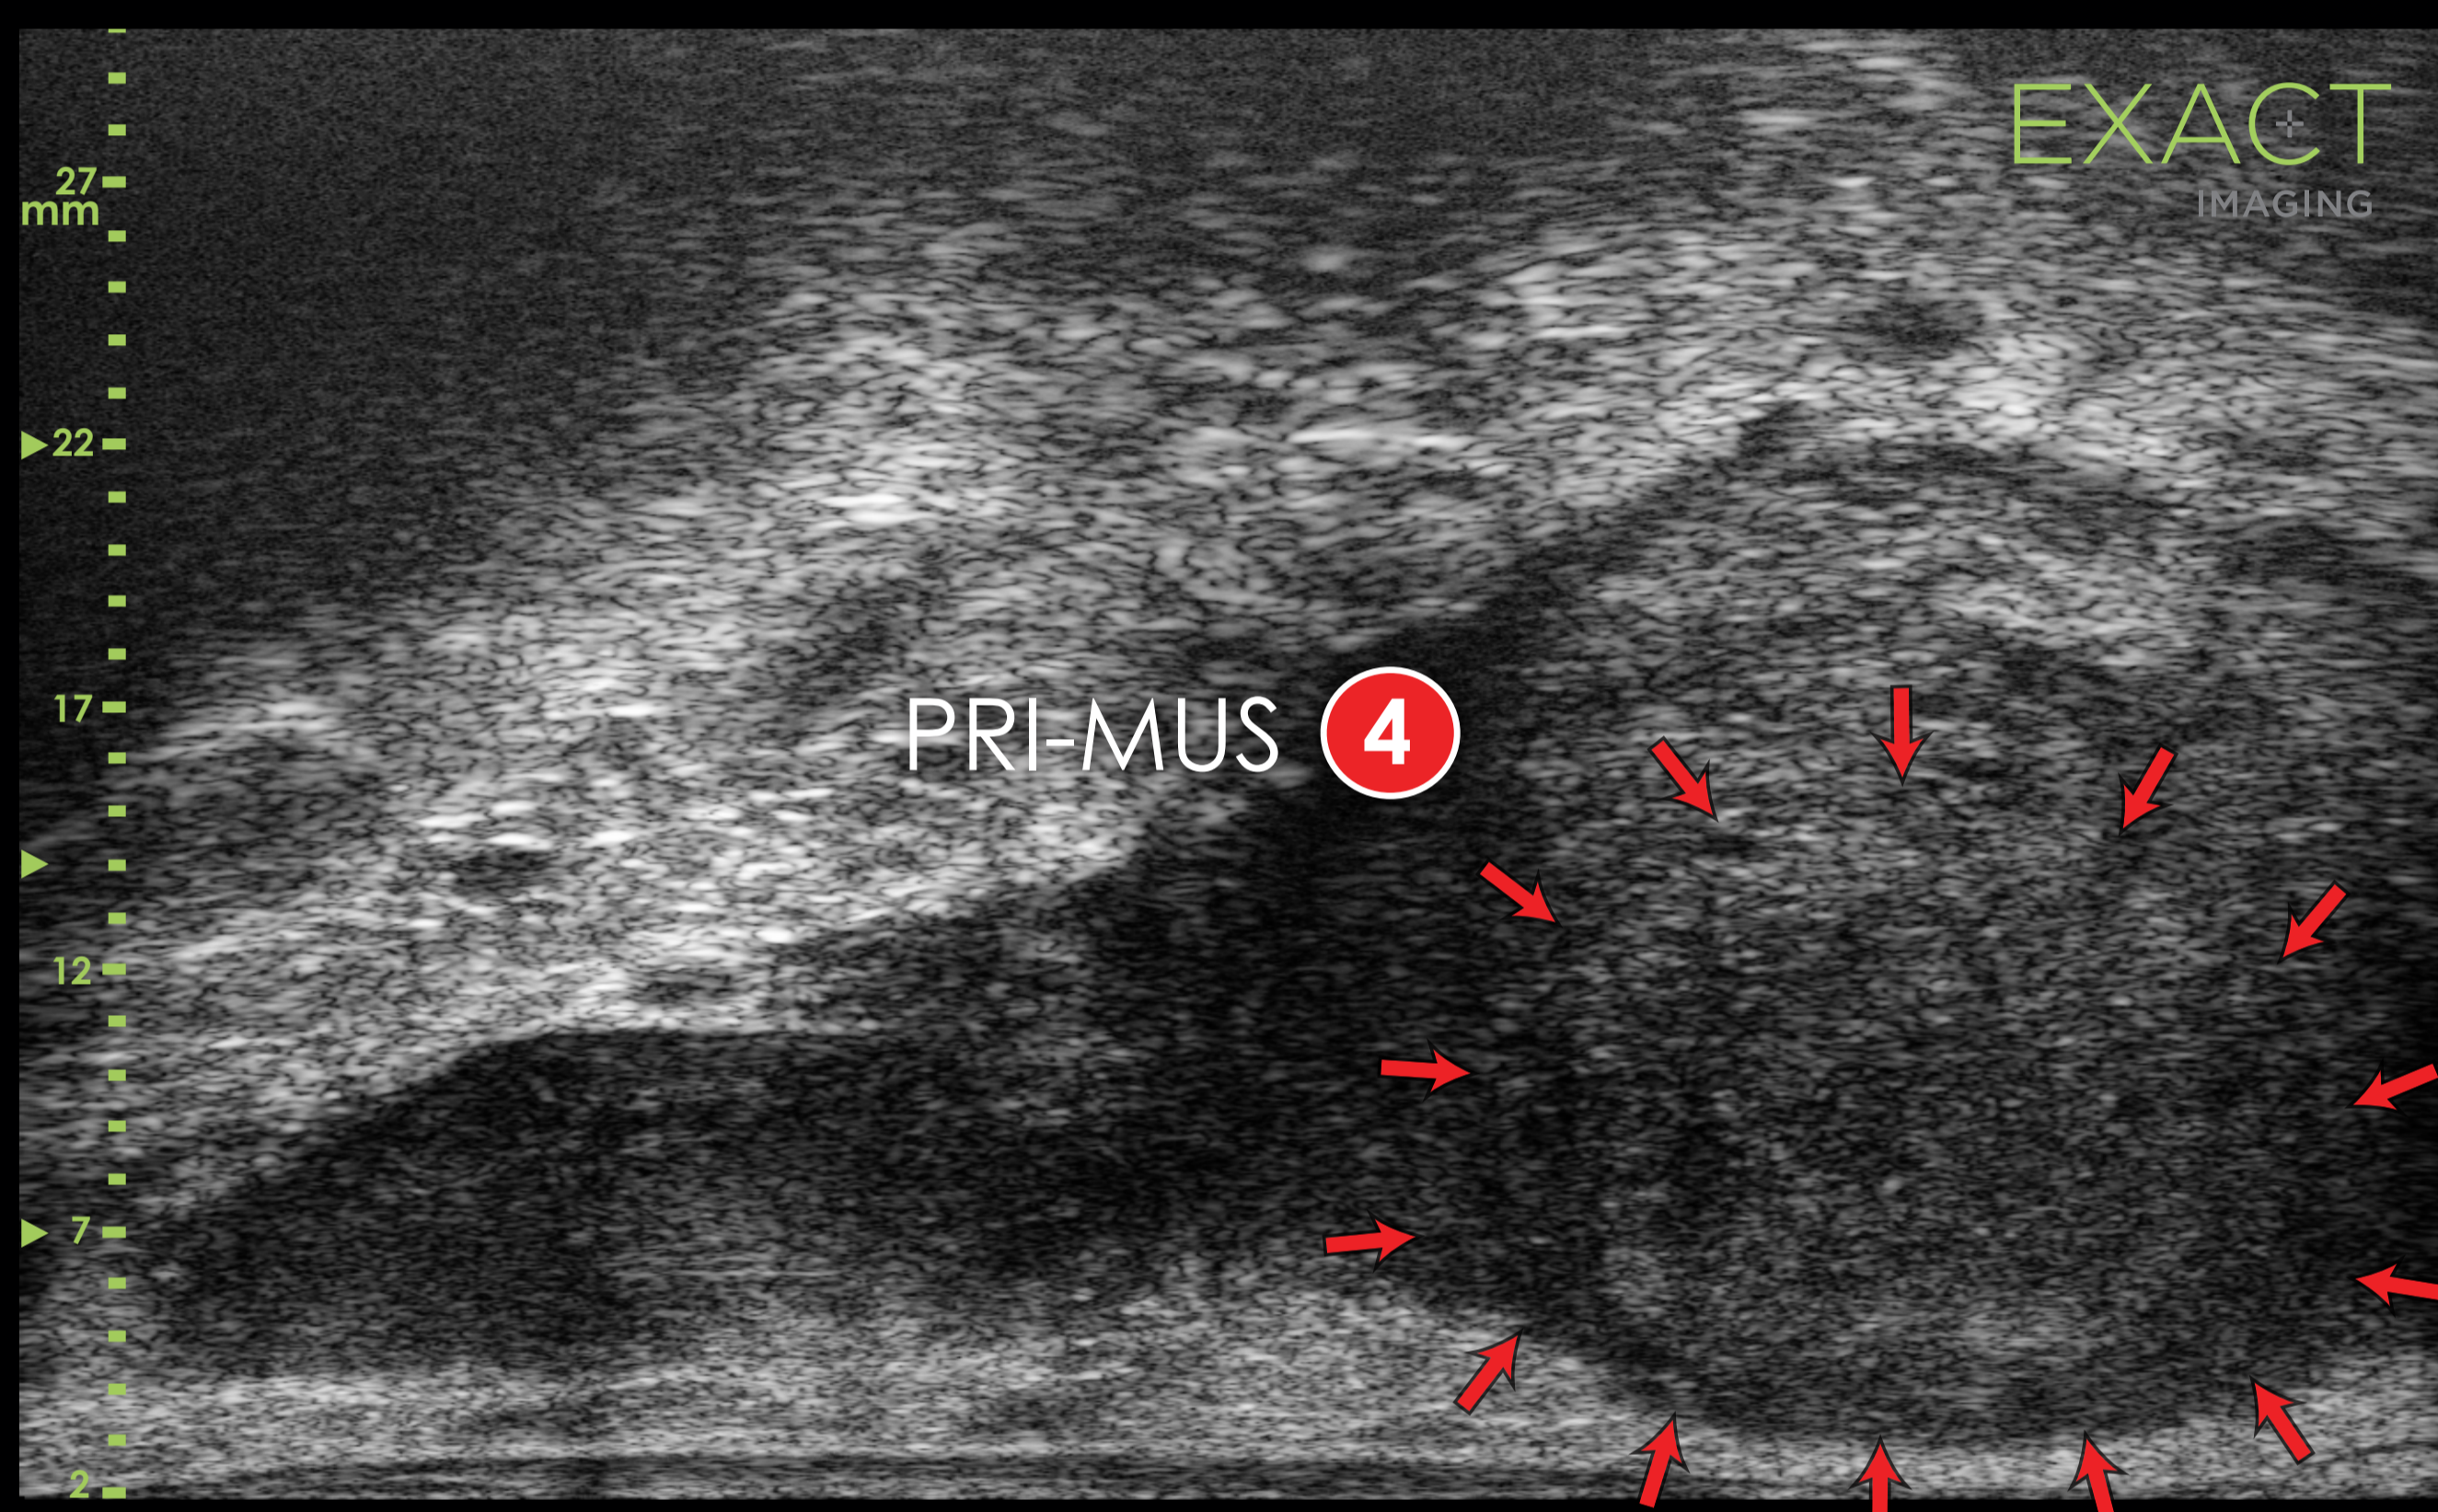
Micro-ultrasound image showing large posterior GG 4 lesion only partially visualized mpMRI. In this case mpMRI suggested a target at the apex only, which was found to contain a lower grade cancer with GG 3, while the more serious GG 4 lesion was focused at the base.
